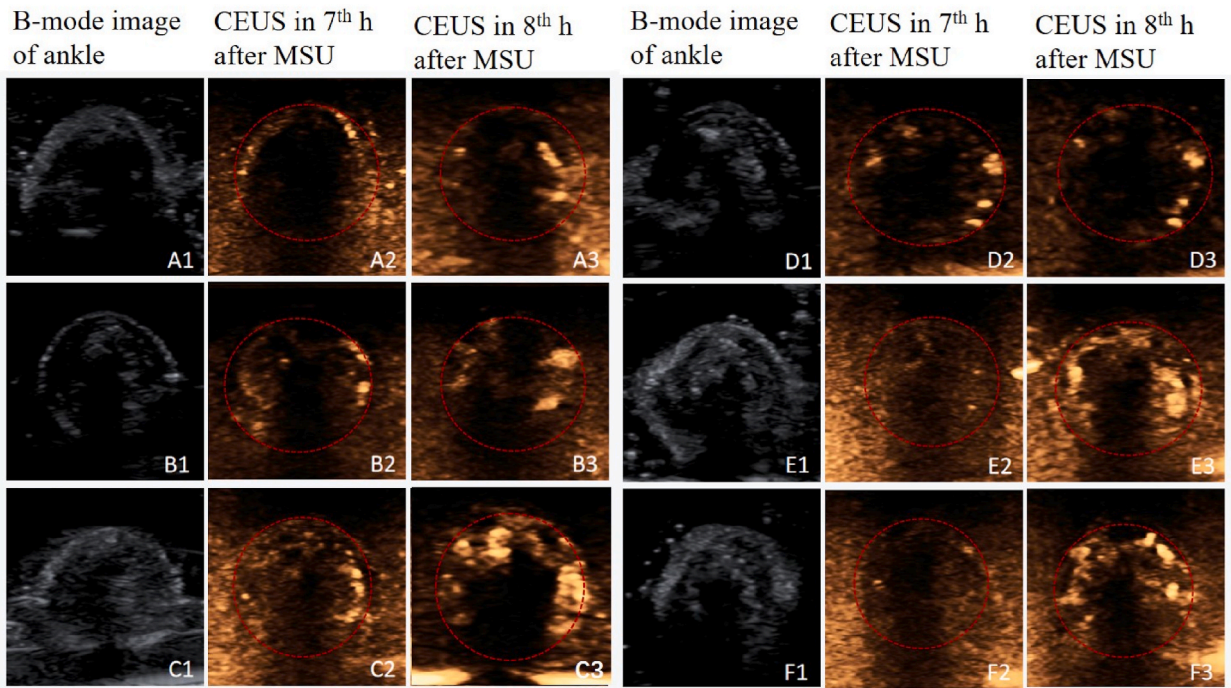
Contrast enhanced ultrasound (CEUS) images before and after cavitation: A: control group, B: model control group, C: cavitation group, D: high dose colchicine group, E: cavitation + low dose colchicine group, F: cavitation + high dose colchicine group. A1, A2, and A3 represent the two-dimensional images of the ankle joint in group A, the CEUS of the ankle joint in group A at 7 h, the CEUS of the ankle joint in group A at 8 h, and so on.
